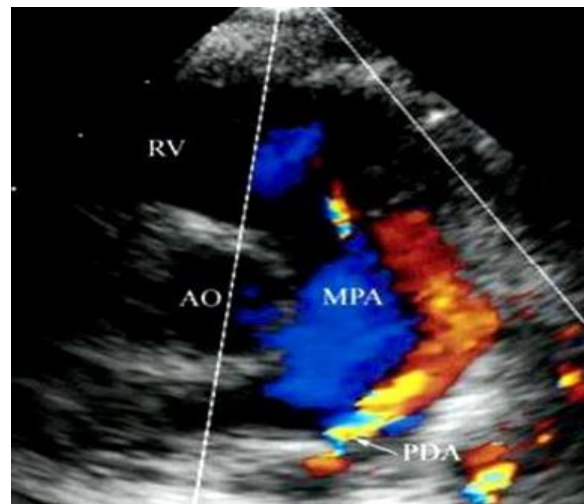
PDA - In the SX view on color flow doppler analysis a continuous flow (red) from the PDA into the main pulmonary artery is displayed. AO, aorta, RV, right ventricle, MPA, main pulmonary artery
